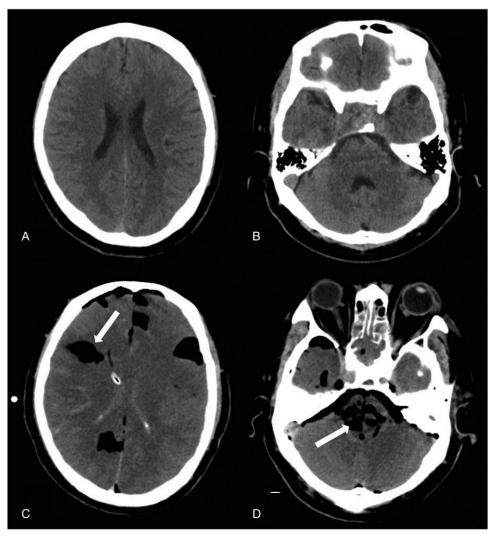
CT scan when the patient fell into coma, showed the ventricle system (A and B) was almost normal, the structure of the brain was clear. CT scan at the 3rd day, showed that there was pneumocrania (C), the ventricle system was squeezed, the CSF signal was high in density, the brain was swelling, the structures of around the brainstem were obscure (D). CT=computed tomography.
